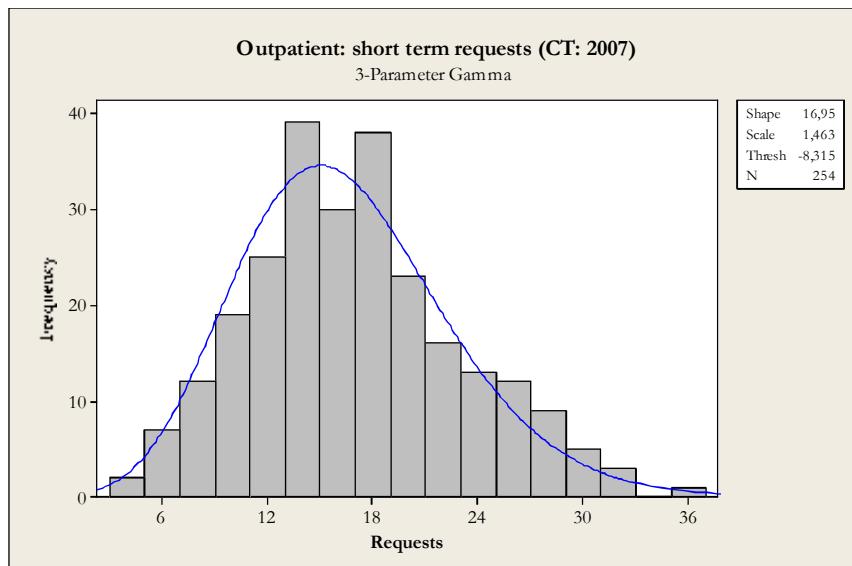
Fitted distribution for short term outpatient CT requests (RIS: 2007). Distribution: Gamma (Shape: 16,95; Scale: 1,46; Threshold: -8,32).
